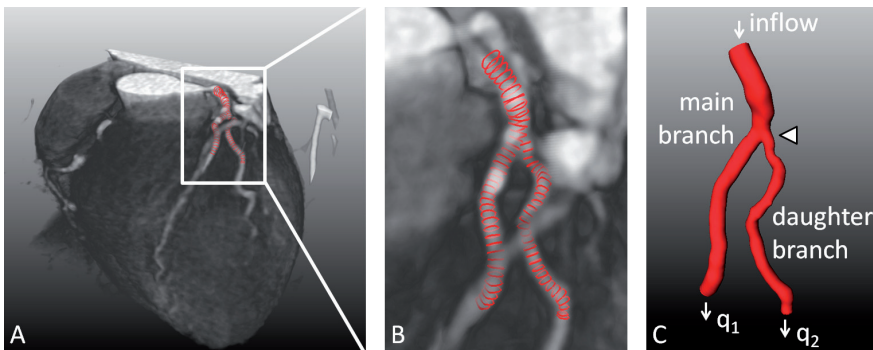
3D reconstruction of a coronary bifurcation based on CTA data. A: 3D visualization of the heart from CTA data. In a section of the LAD and the first diagonal contours of the lumen were segmented (red). B: Close-up of panel A. C: Based on the contours a 3D volume was generated that was used for flow computations. The white triangle indicates the diseased portion of the vessel. q_1 and q_2 indicate the two outflows of the bifurcation.
